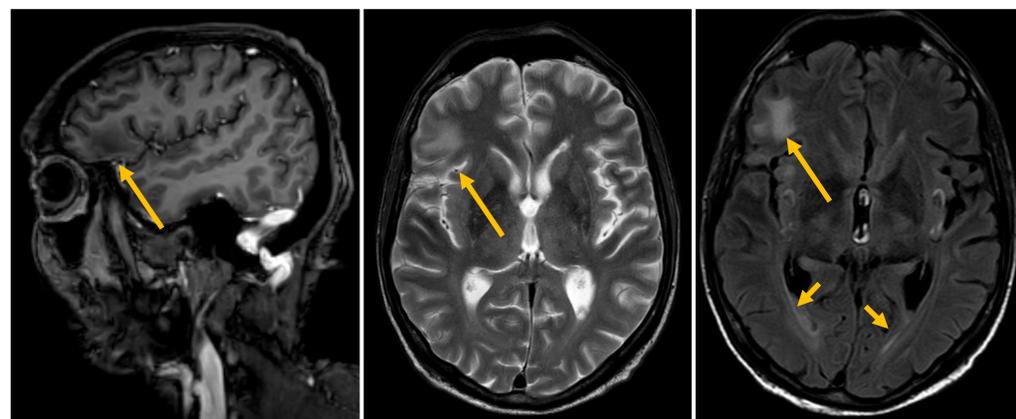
Edema in the right frontal lobe and FLAIR inhomogenities on MRI (T1, T2 weighted and FLAIR images)
